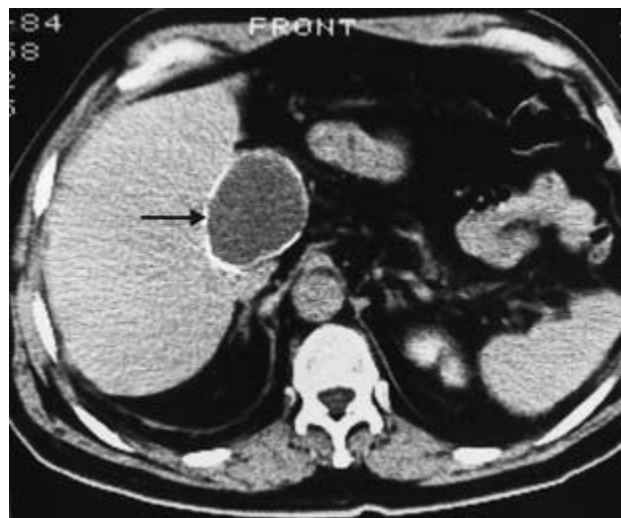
CT scan shows calcified hydatid cyst (arrowed) in a quadrate lobe of the liver (contrast-enhanced scan).
